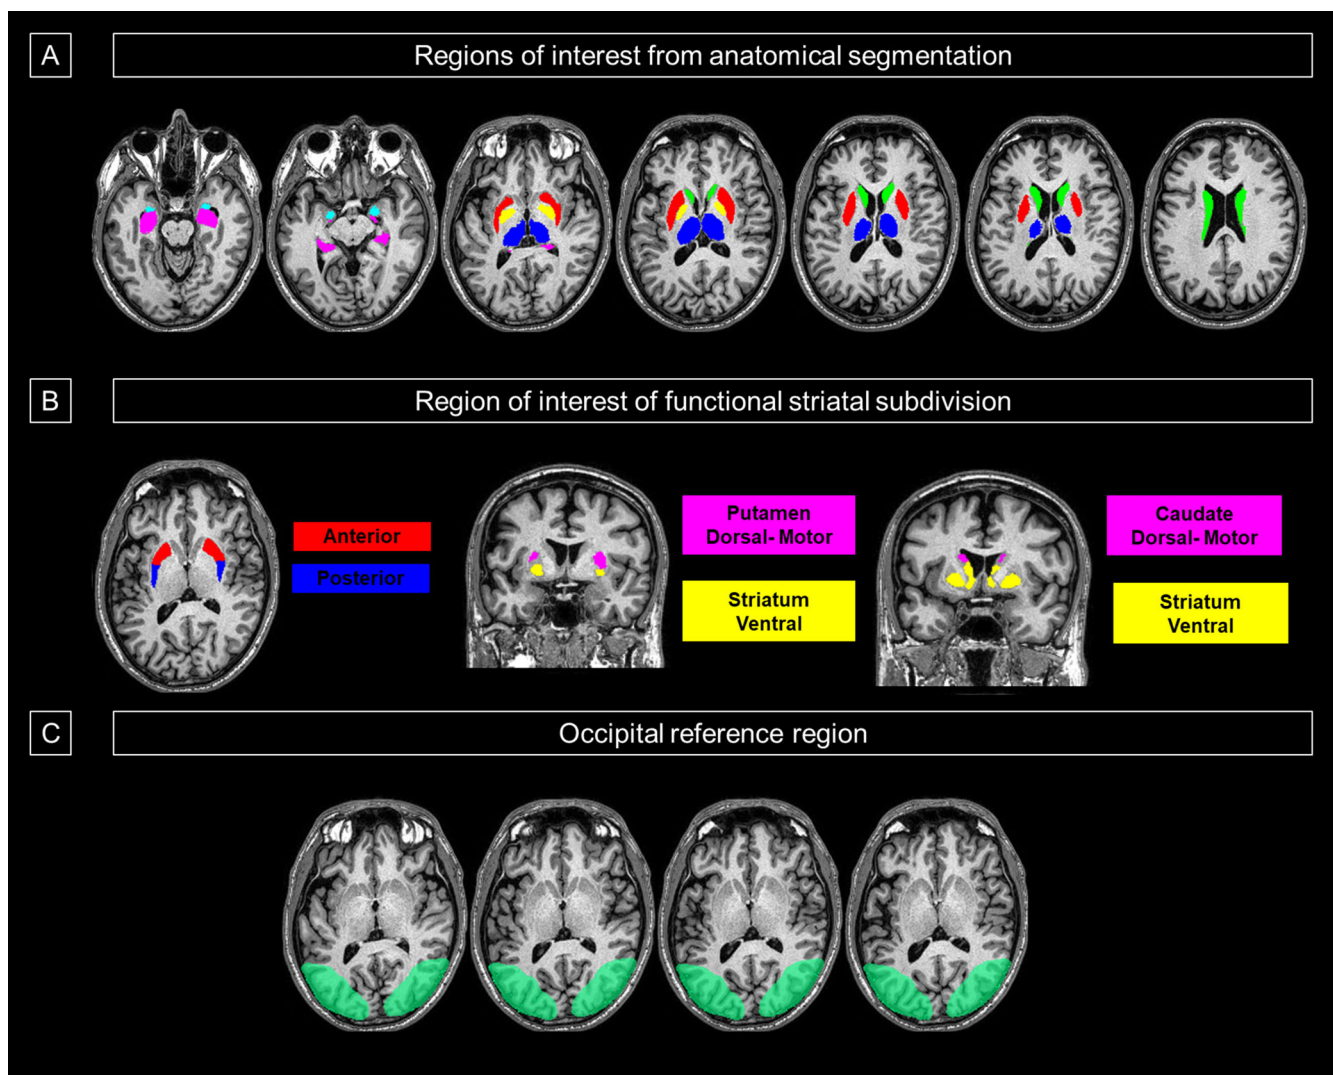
Subject-specific regions of interest (ROIs). Example of anatomical subject-specific ROIs superimposed on the relative magnetic resonance imaging (MRI)-T1 image in the native space of a glucosylceramidase-associated Parkinson's disease (GBA-PD) patient. (A) ROIs obtained by the automatic anatomical segmentation of MRI scan, performed using volbrain. Twelve bilateral ROIs were defined in each subject: whole caudate nucleus (green), whole putamen (red), globus pallidus (dark yellow), thalamus (blue), hippocampus (pink), and amygdala (light blue). (B) The functional striatal subdivision following literature guidelines. The right panel shows the anterior (red) and posterior (blue) subdivisions of the whole putamen. The boundary between the anterior and posterior putamen was taken to be the posterior aspect of the fornix. The left panel shows a functional subdivision of the striatum based on a multimodal imaging study.²⁵ The functional subdivision of the striatum includes dorsal-motor (pink) and ventral (yellow) divisions. (C) This panel displays the lateral superior occipital cortex ROI used as the background reference region to calculate standard uptake value ratio (SUVr) values. [Color figure can be viewed at wileyonlinelibrary.com]
